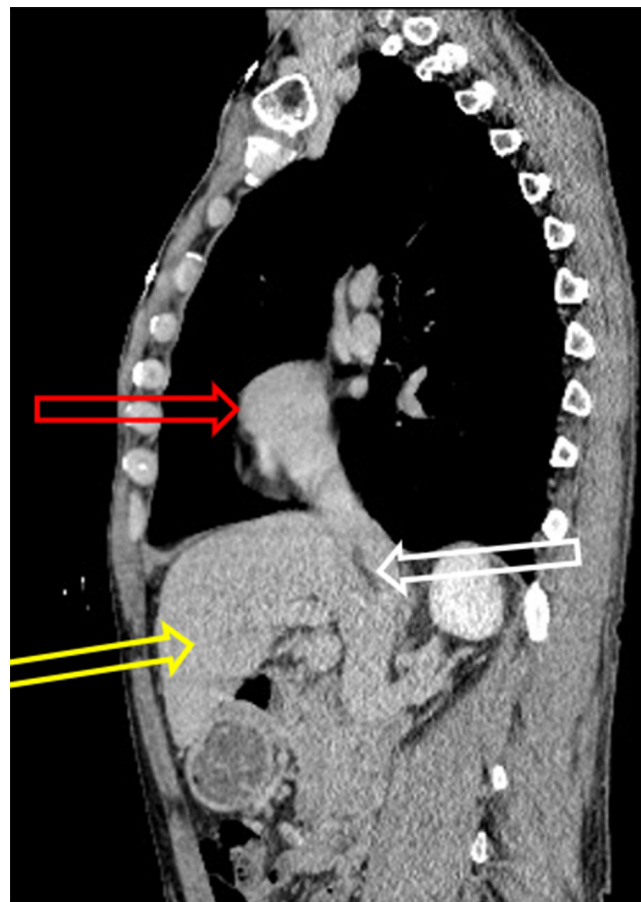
Computed tomography (CT) angiography of the chest, abdomen, and pelvis from the second admission showing a nonocclusive inferior vena cava (IVC) thrombus (white arrow) emanating from the accessory right hepatic vein (RHV). Also seen is the liver (yellow arrow) and the right atrium (red arrow).
